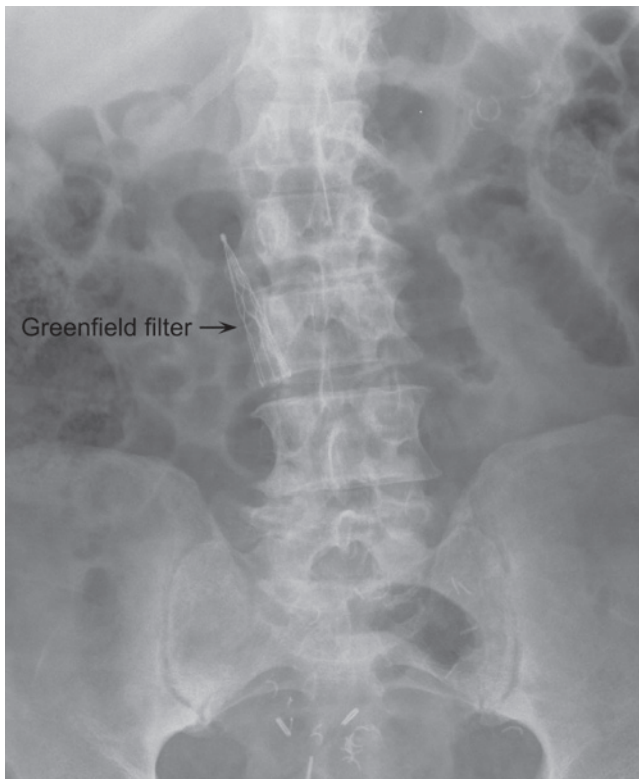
Partial deployment of this Greenfield filter was documented by abdominal radiograph.
